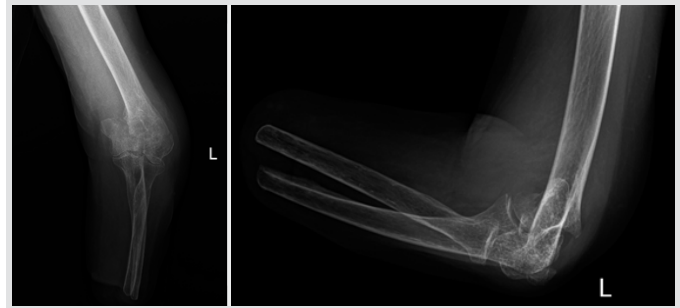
Initial radiographs of the left elbow. Left: Anteroposterior view and right: Lateral view.
